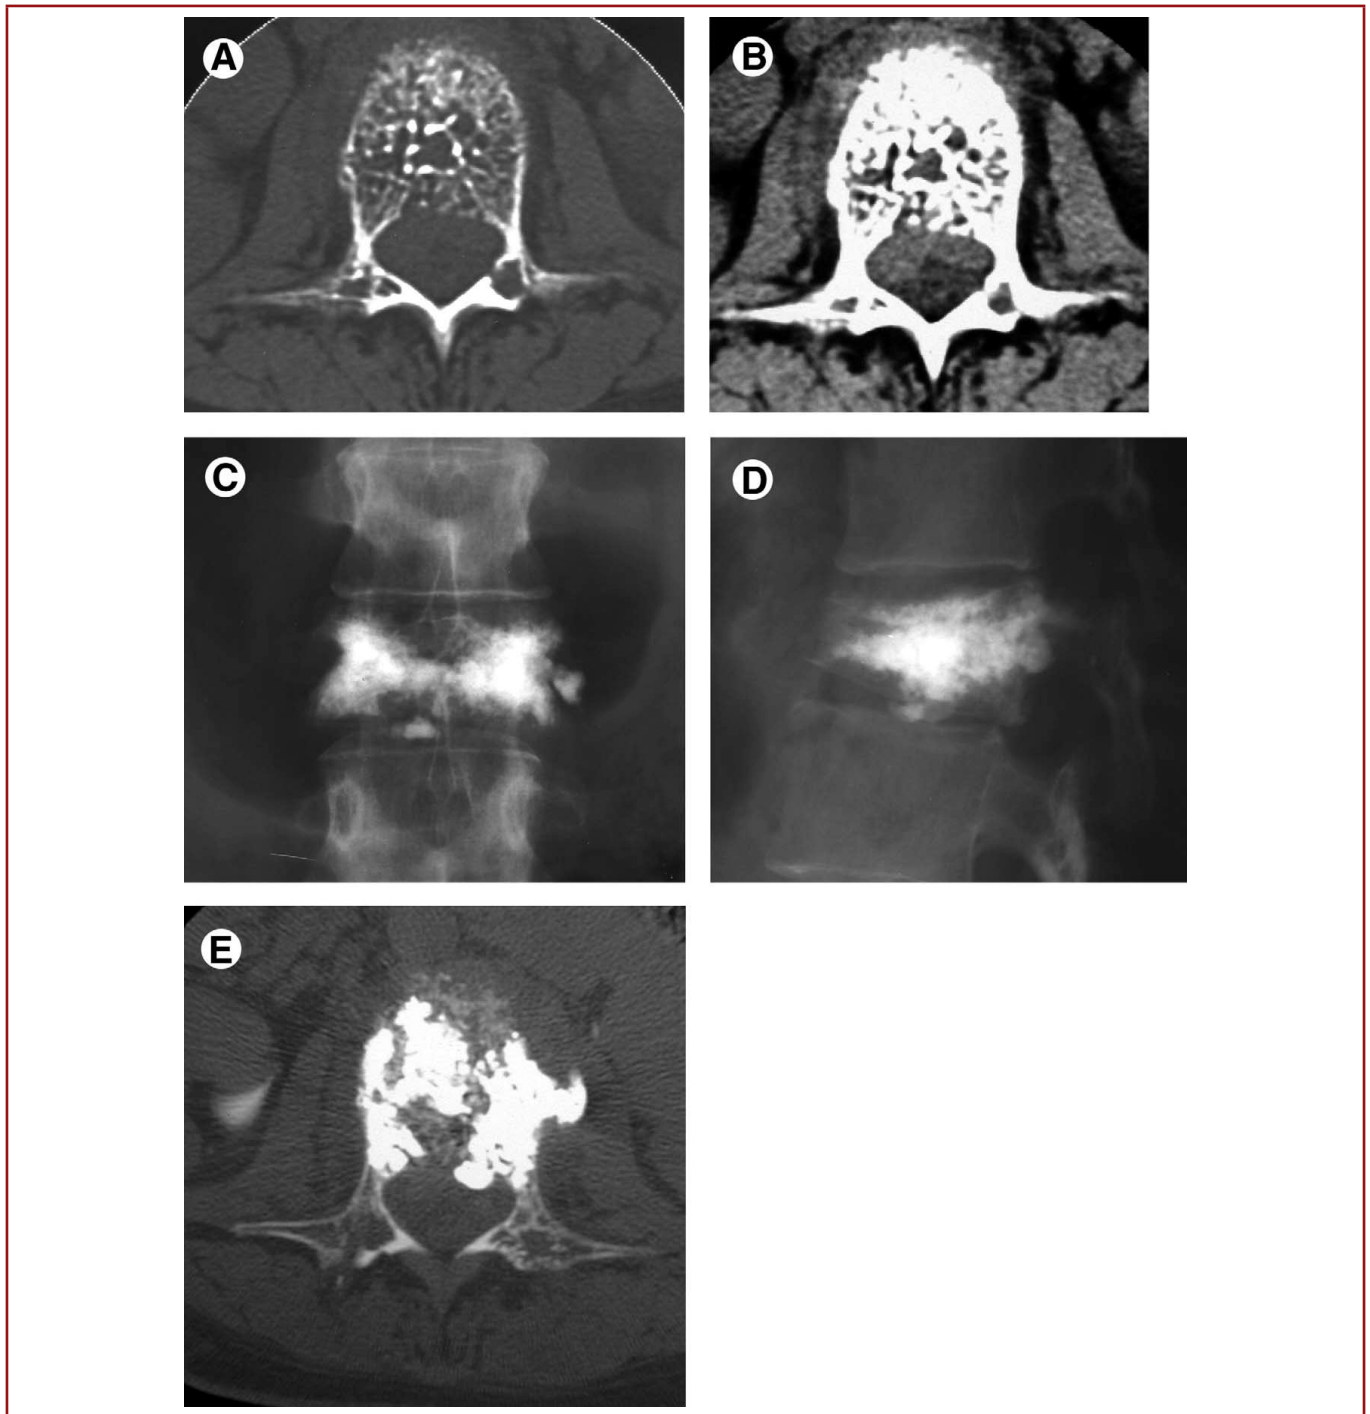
Aggressive hemangioma of L2, Preoperative CT scan appearance of L2 showing tumoral extension into the anterior epidural space (A and B). Anteroposterior and lateral radiographs after vertebroplasty (C and D). Postvertebroplasty CT scan (E).
